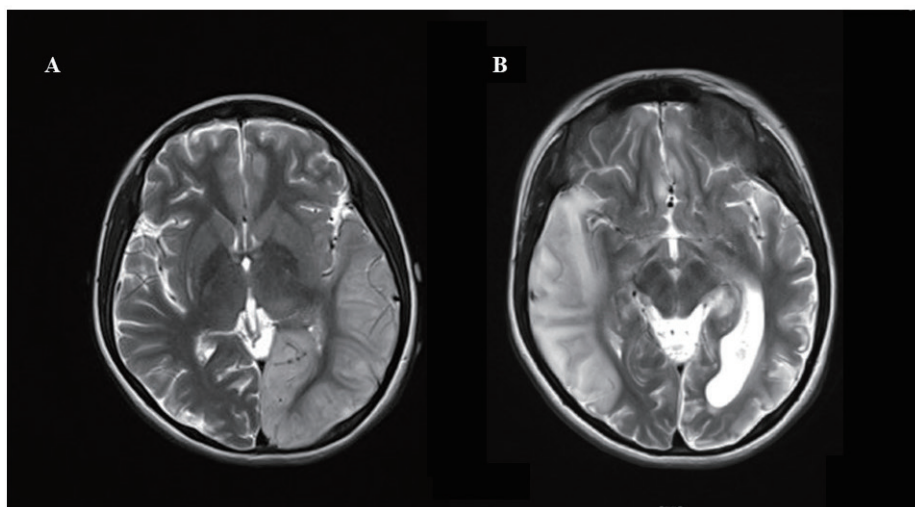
At 16- years- 7- month old, MRI of brain showed long T2 edema in left parieto-occipital lobe (A). Presence of a large area long T2 edema in right temporo-parieto-occipital lobe, and dilatation of the occipital horn of left lateral ventricle at 16- years- 10- month old.
